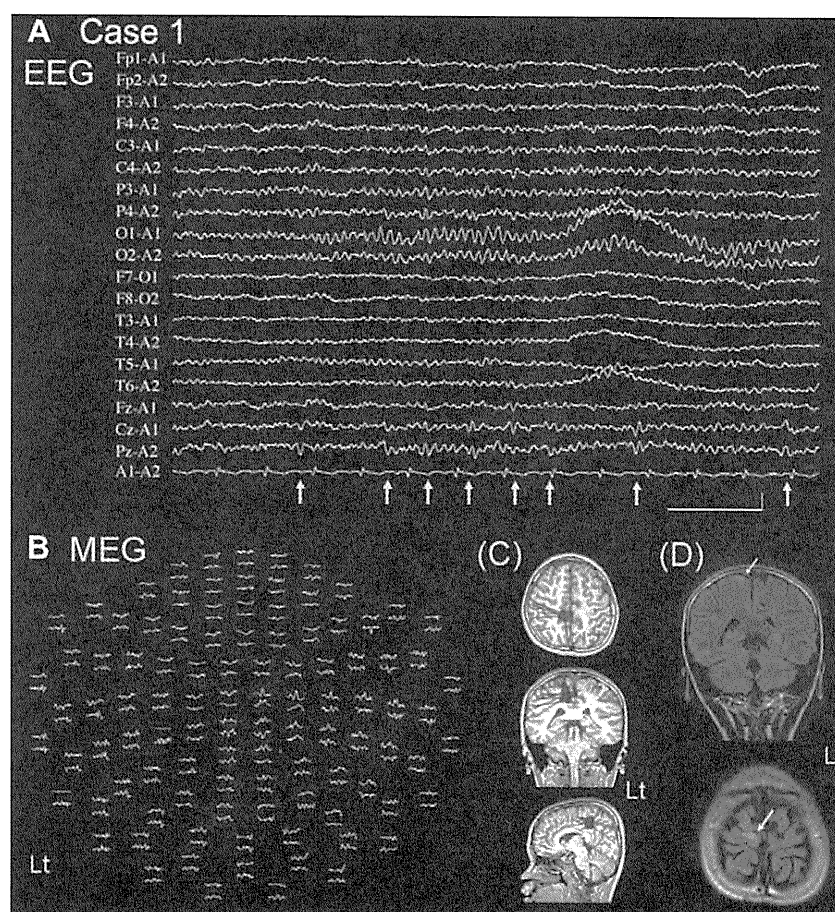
EEG, MEG and MRI of case 1. (A) EEG showed interictal spikes on readings from Fz and Cz electrodes (white arrows). (B) MEG showed spikes in the right frontal area. (C) Equivalent current dipoles from MEG were localized to the top of the primary motor area in the right frontal lobe (red dots). (D) FLAIR MRI image showed high signal region at the top of the primary motor area in the right frontal lobe (yellow arrows).
